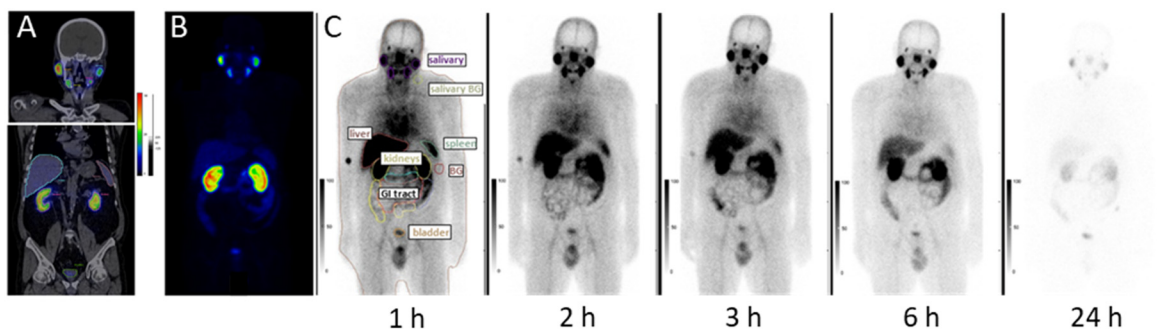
Source organ segmentations in a healthy volunteer. (Patient 3) (A) Organ contours on a fused  $^{99m}\text{Tc}$ -PSMA-I&S SPECT/CT scan, (B) on the SPECT 3D MIP, and on planar scintigraphy images (C). Whole body anterior and posterior  $^{99m}\text{Tc}$ -PSMA-I&S scintigraphy was performed at 1, 2, 3, 6 and 24 hours post-injection.
